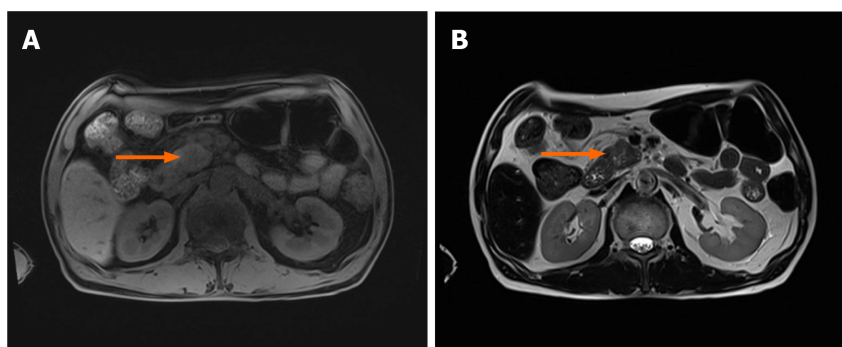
Magnetic resonance imaging. A and B: An approximately 3 cm, ill-defined, space-occupying lesion in the inferior aspect of the head with high signal intensity on T1- and T2-weighted imaging (orange arrows).
